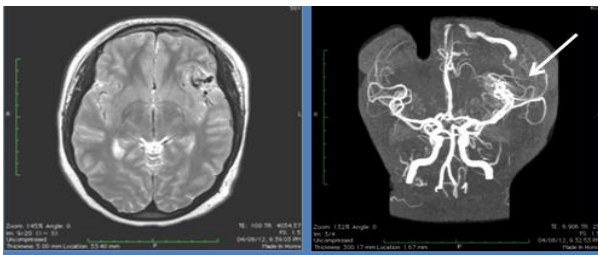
MRI Brain and MR Angio at presentation (Aug 2012)
